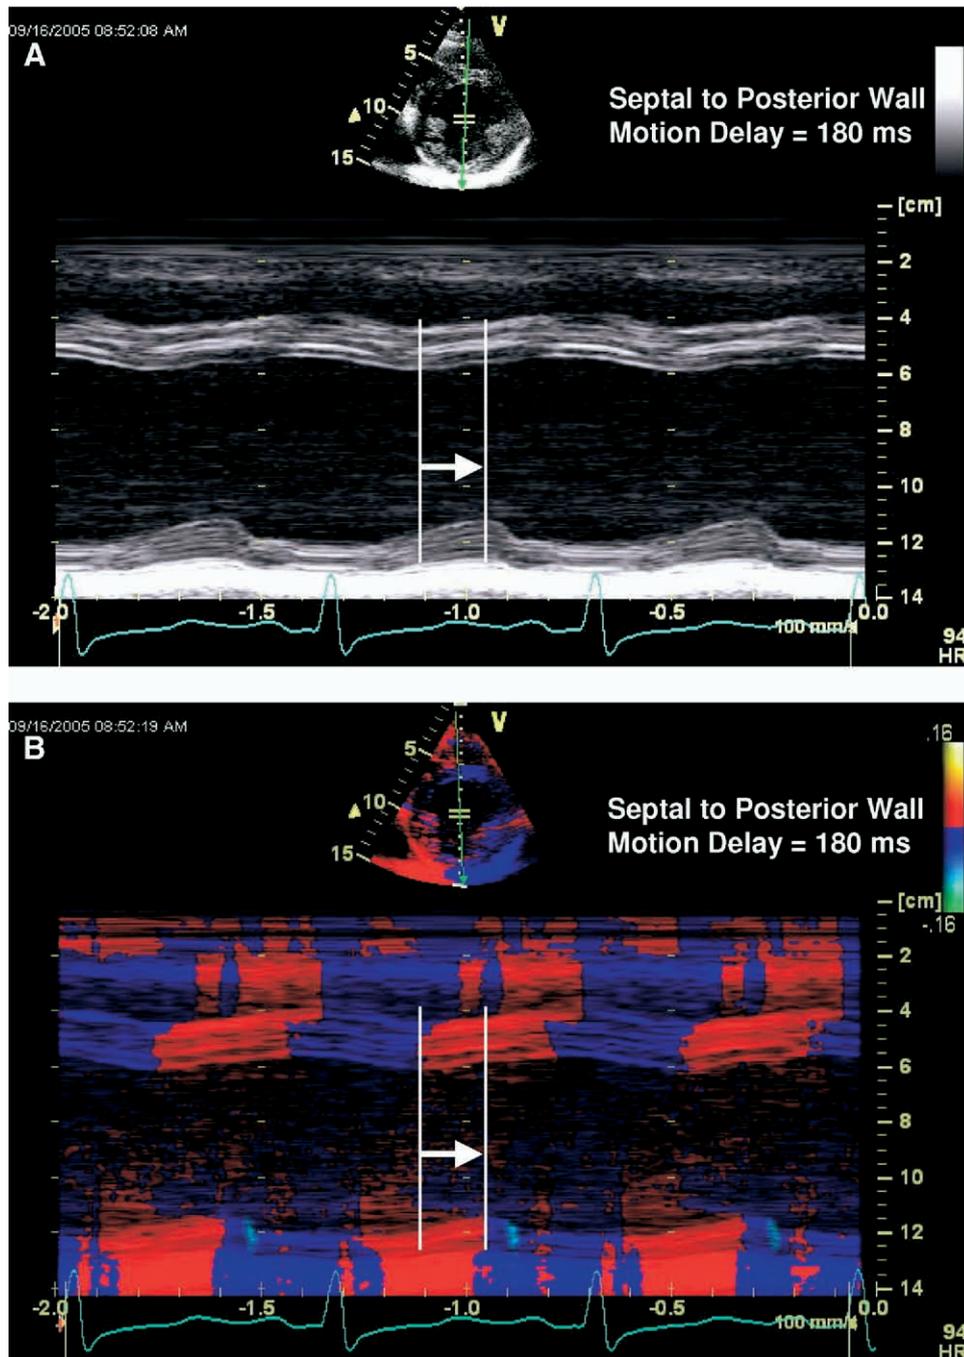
Routine M-mode (A) at midventricular level and color-coded tissue Doppler M-mode (B) demonstrating septal to posterior wall delay of 180 milliseconds, consistent with significant dyssynchrony (≥ 130 milliseconds).
